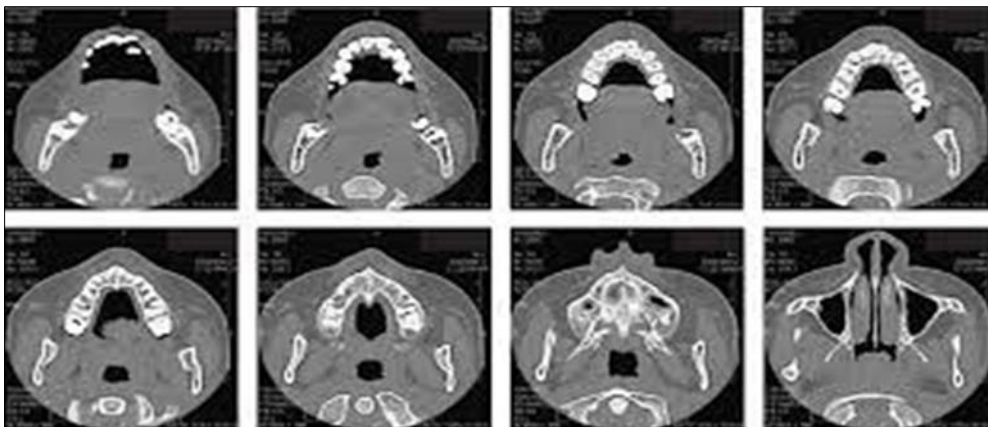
Radiological image made by Fan Beam Computed Tomography of the craniofacial region in sequential section in the axial plane. Modified from Silva et al. 2017 [25]
